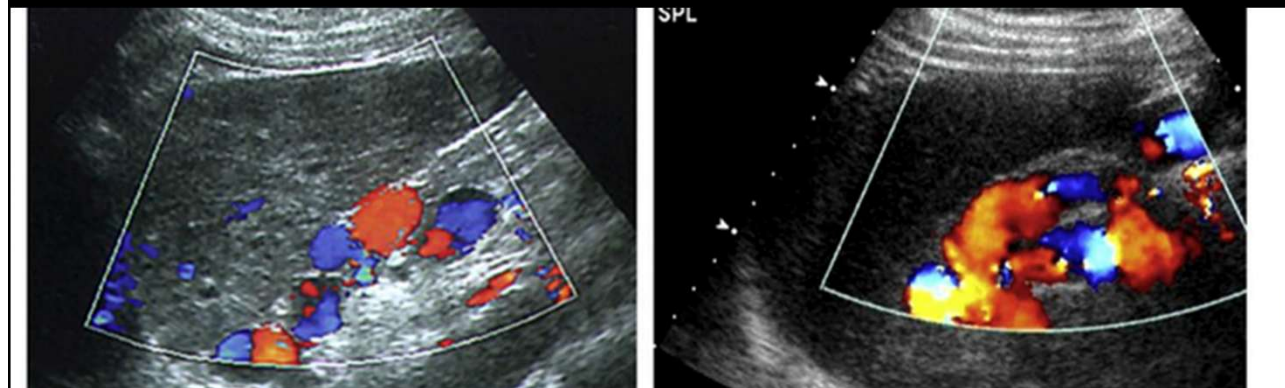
Color Doppler image of esophageal varices.
